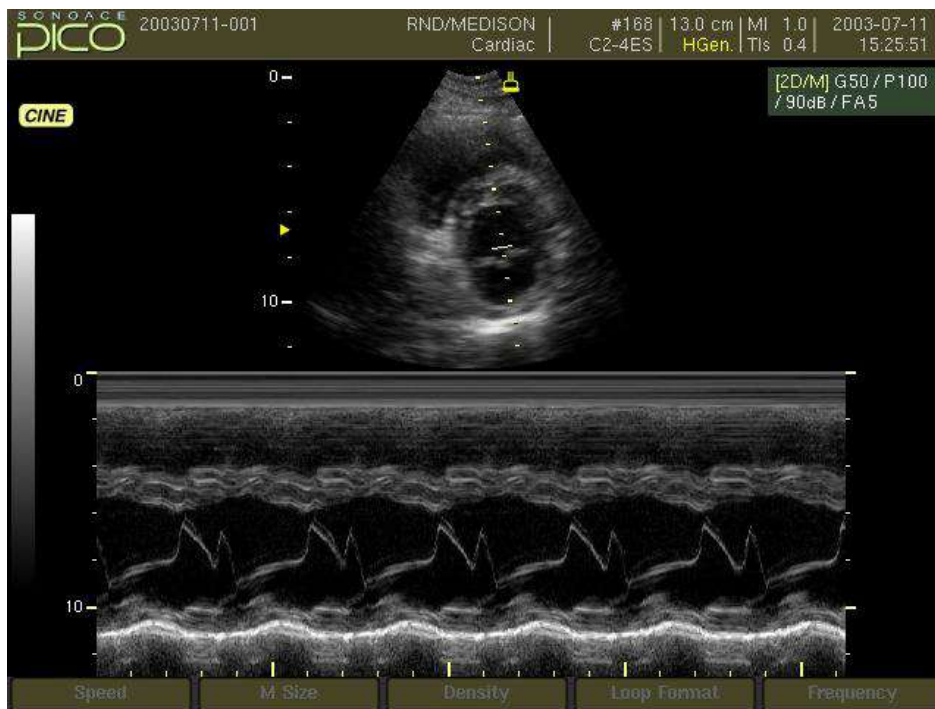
A sample M-mode ultrasound image
